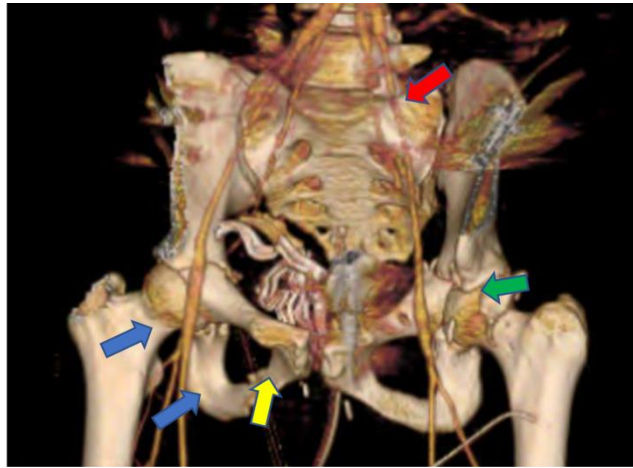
Figure IX (Case two): CT pelvis 3-D reconstruction (anteroposterior view) showing right sided superior and inferior pubic rami fractures (blue arrows), reduced pubic symphysis (yellow arrow) and disrupted contralateral left sacroiliac joint (red arrow). Although the left hip is reduced, a large displaced fragment of the posterior acetabular wall can be seen lying superior to the femoral head (green arrow).
